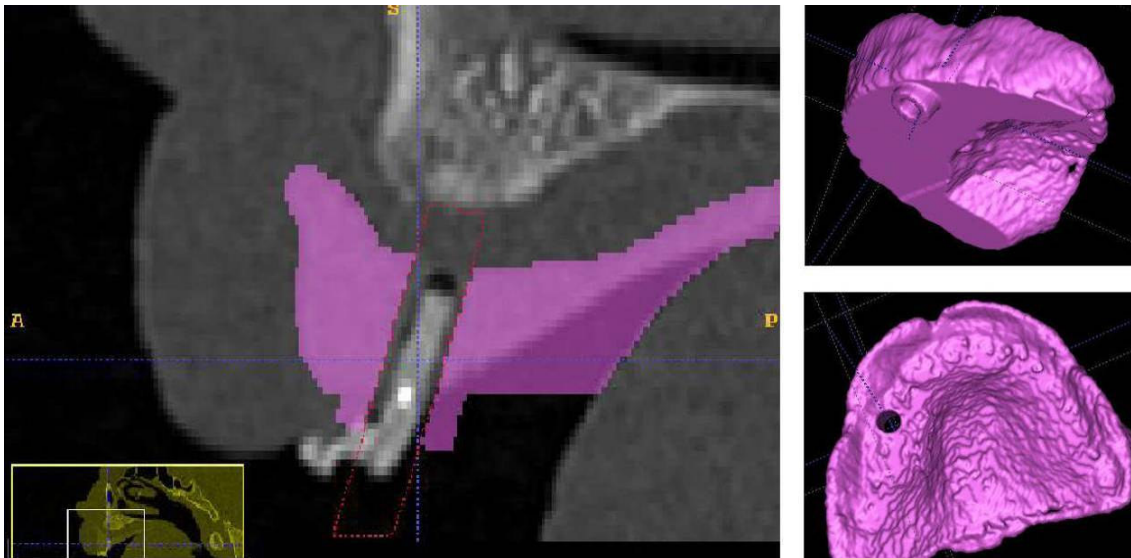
Dental implantology tool. (left) Dental plant axes positioning on the CT images and cylinder drilling guide dimensions setting. (Right) Rendering of the surgical guide with the hole for the metal bush.
